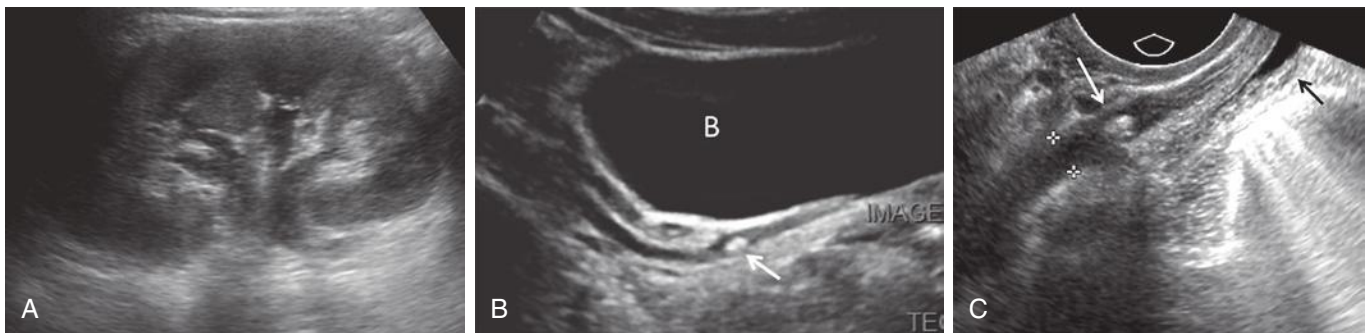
Urolithiasis in patient with right pelvic pain. A, Sagittal gray-scale ultrasound image of the right kidney demonstrates mild dilatation of the intrarenal collecting system. The uterus and adnexa were normal (not shown). B, Transabdominal scan, using the distended urinary bladder (B) as an acoustic window, demonstrates an echogenic calculus (arrow) in the mildly distended, fluid-filled distal right ureter. C, Transvaginal scan demonstrates an echogenic calculus (white arrow) in the dilated distal ureter (calipers) just proximal to the ureterovesical junction. The bladder (black arrow) is decompressed.
